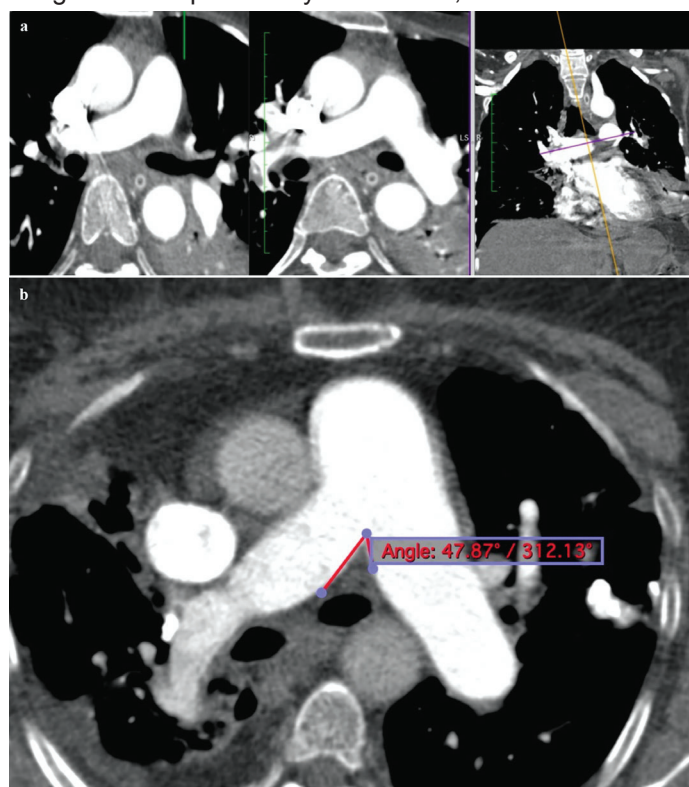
Axial pulmonary CT angiography (a) shows the reconstruction technique of the axial CTA images; the bifurcation angle measurement (b) is performed on axial lung CTA images at the level of pulmonary artery bifurcation.
